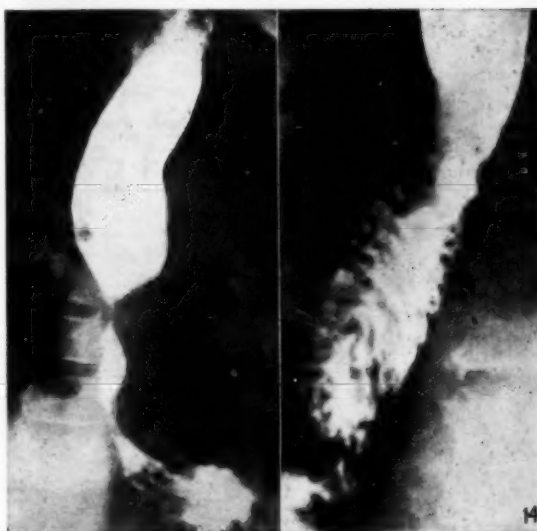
This radiograph is from a 14-year-old boy who was treated by oesophageal dilatations and medically for 9 years. Despite this, oesophageal obstruction became complete and oesophago-jejunostomy was performed.
